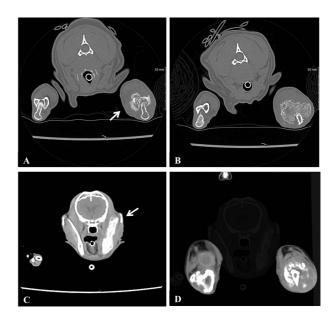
(A) Transverse CT images (15 days after first presentation) showing an amorphous periosteal response with adjacent cortical thinning (arrow) in the distal aspect of the left humerus. (B) Transverse CT images obtained before amputation showing a severe irregular mixed lytic and productive lesion with more extensive and permeative progress in the distal aspect of the left humerus compared to the previous image. (C) and (D) Transverse CT images (right before euthanasia) showing an amorphous periosteal reaction in the left mandibular (C, arrow), bilateral soft tissue edema and cortical destruction with a prominent periosteal reaction (D).
